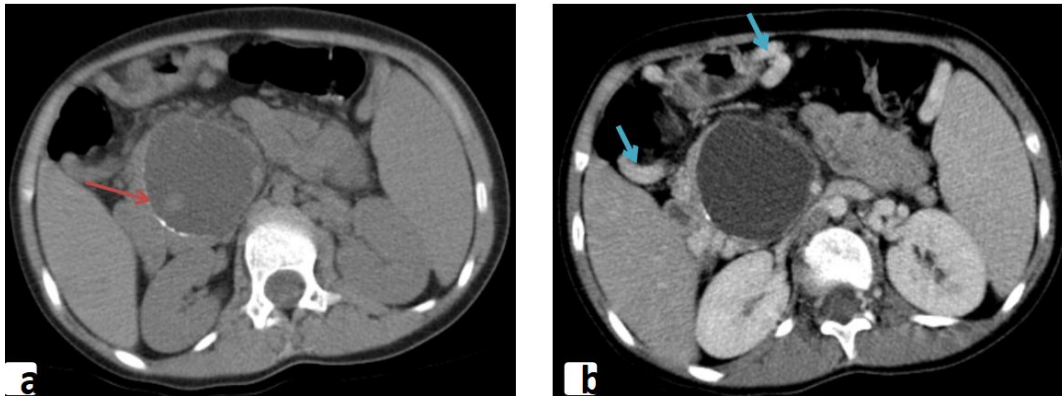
Abdominal CT scan; a) axial cut in spontaneous contrast, b) axial cut after injection of contrast product in the venous phase: which showed a mass on the head of the pancreas, with a partially calcified wall (red arrow) and low-density mass with fat content, measuring 55 x 54 mm, it compresses the portal vein causing a serpiginous and dilated venous at the hepatic hilum and peri gastric (bleue arrow)
